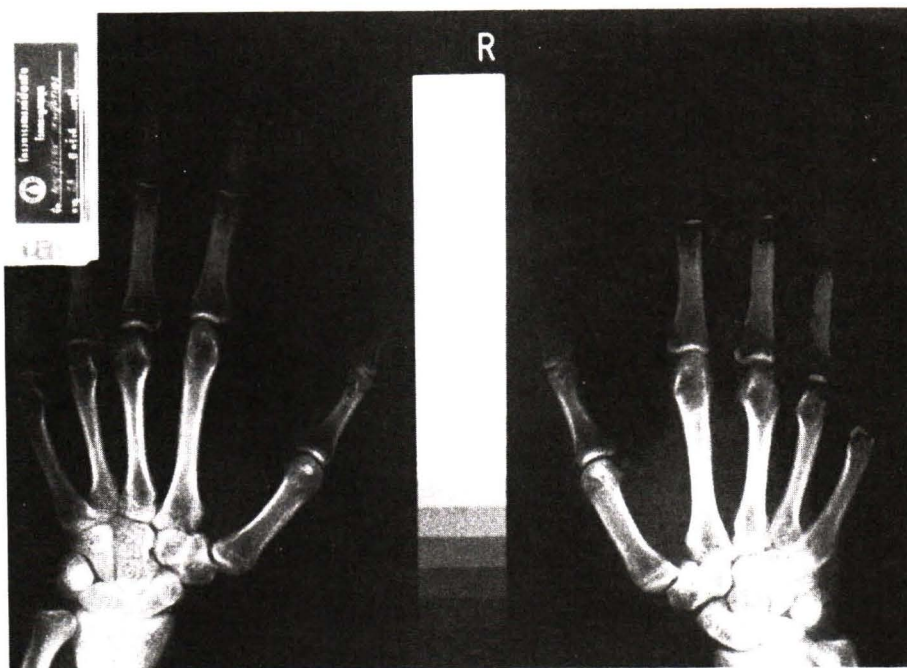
Taking an X-ray image of the hands along with an aluminium step wedge.
